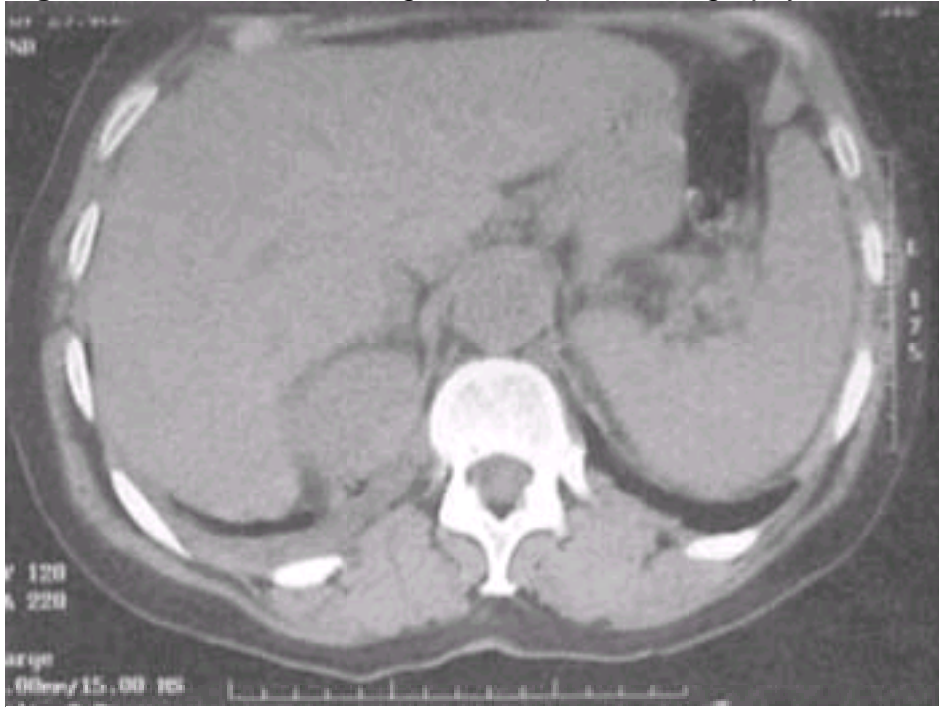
Pleural effusion. Sickle appearance of a free-flowing pleural effusion on computed tomography scan.
